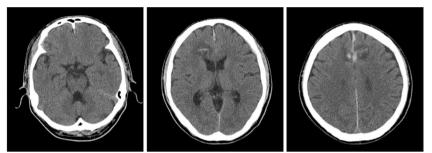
Initial computed tomography images. Computed tomography demonstrating a scanty subdural hematoma at right frontal skull base and left falx and intracerebral hematoma at both frontal lobes.
